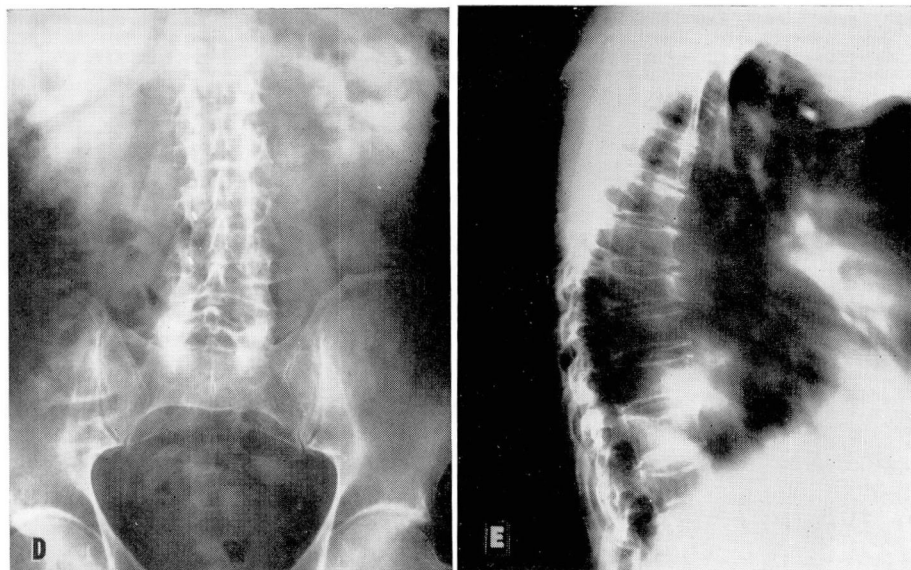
Progress roentgenograms taken in April, 1965, showing: D and E, no evidence of recalcification and compression of sixth, seventh, eighth, and ninth thoracic vertebrae.
